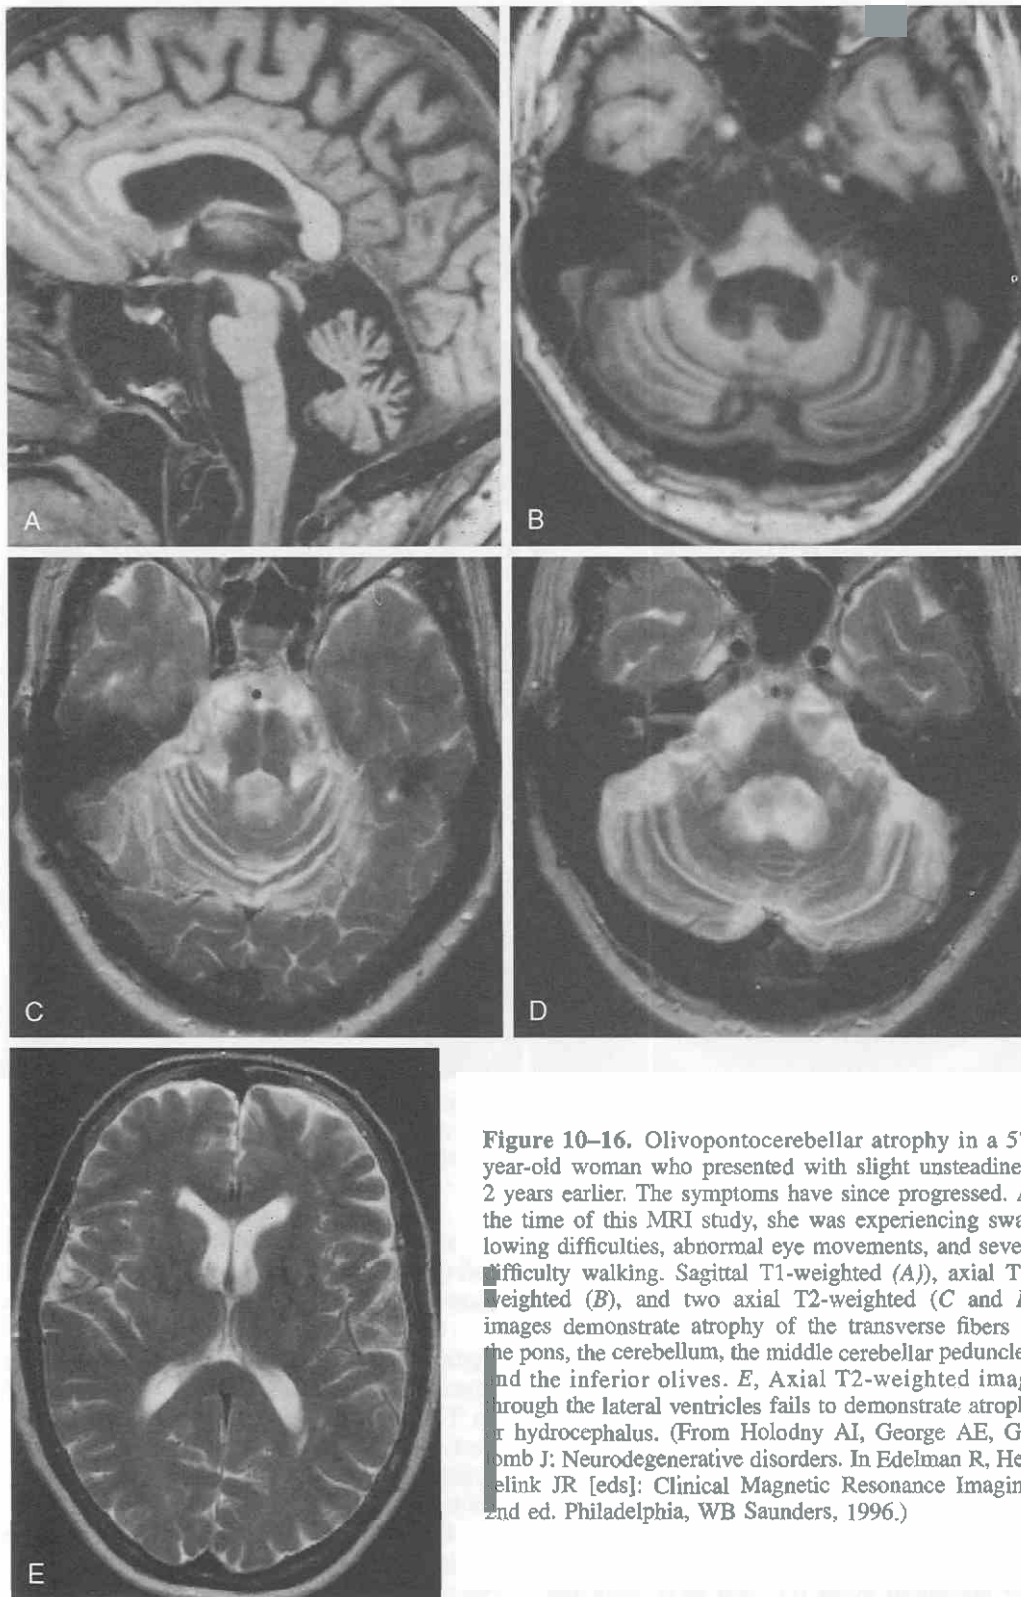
Olivopontocerebellar atrophy in a 57-year-old woman who presented with slight unsteadiness 2 years earlier. The symptoms have since progressed. At the time of this MRI study, she was experiencing swallowing difficulties, abnormal eye movements, and severe difficulty walking. Sagittal T1-weighted (A), axial T1-weighted (B), and two axial T2-weighted (C and D) images demonstrate atrophy of the transverse fibers of the pons, the cerebellum, the middle cerebellar peduncles, and the inferior olives. E, Axial T2-weighted image through the lateral ventricles fails to demonstrate atrophy or hydrocephalus. (From Holodny AI, George AE, Gomb J: Neurodegenerative disorders. In Edelman R, Hesselink JR [eds]: Clinical Magnetic Resonance Imaging, 2nd ed. Philadelphia, WB Saunders, 1996.)
